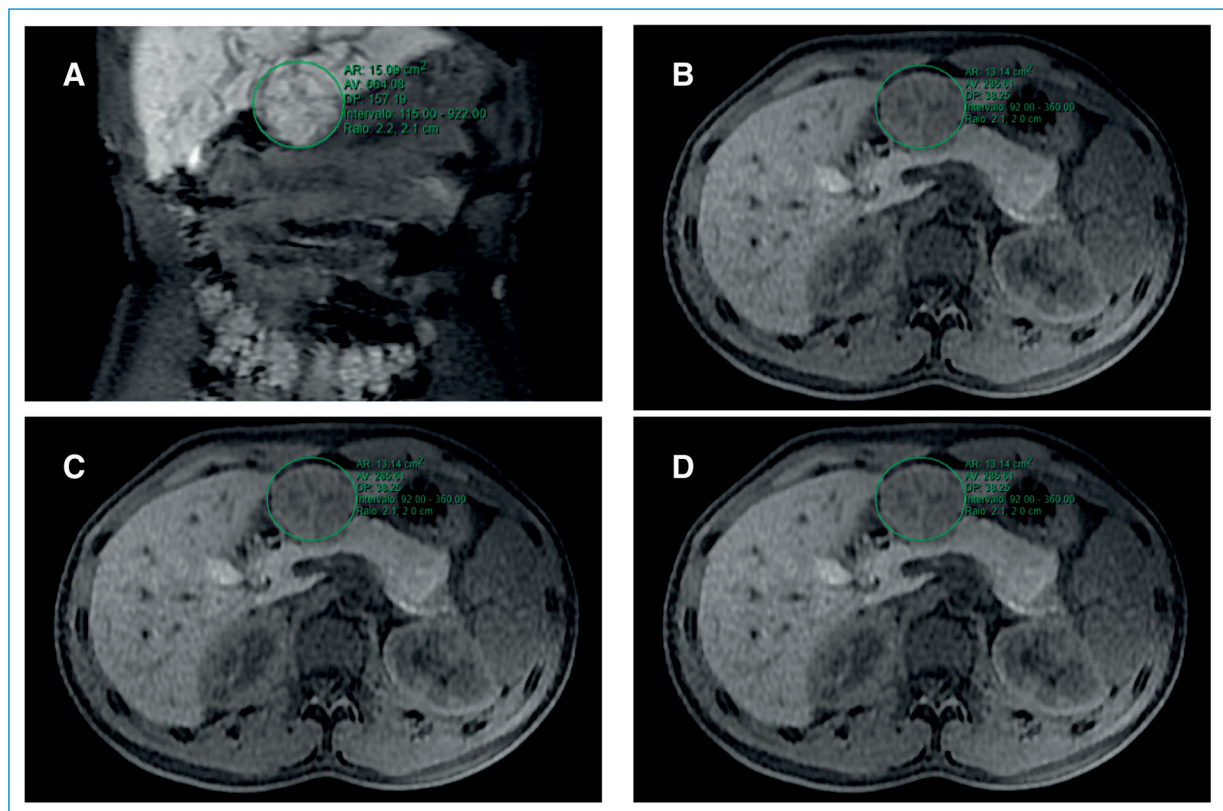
Abdominal diffusion-weighted magnetic resonance imaging with gadolinium contrast showing a nodular lesion in the third segment of the left hepatic lobe, characterized by well-defined and lobulated margins (A). It appeared hypointense on T1-weighted images (B) and hyperintense on T2-weighted images (C). The lesion showed arterial enhancement, except for the central scar, following contrast injection, becoming isointense during the portal venous phase, and exhibited enhancement in its central region thereafter (D). The highlighted imaging features are characteristic of, and diagnostic for, focal nodular hyperplasia.
